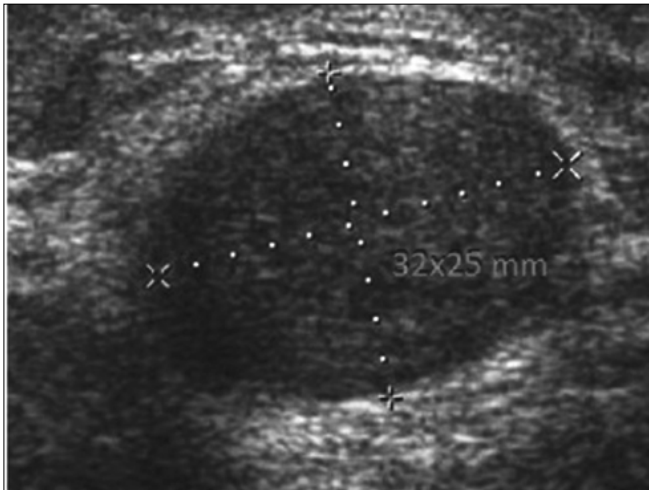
A hypoechoic and round shaped mass with dimensions of 32 to 25 mm on ultrasound examination.
